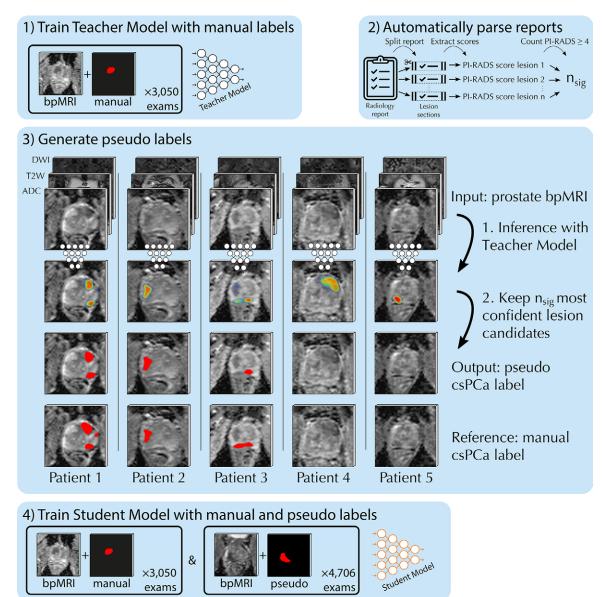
Overview of the semisupervised learning method for malignancy detection: (1) train the teacher model with manual labels; (2) count the number of clinically significant lesions described in the report, $n_{sig'}$ (3) localize and segment the lesions, by keeping the n_{sig} most confident lesion candidates of the teacher model; (4) train the student model with manual and pseudo labels. ADC = apparent diffusion coefficient, bpMRI = biparametric MRI, csPCA = clinically significant prostate cancer, DWI = diffusion-weighted imaging, PI-RADS = Prostate Imaging and Reporting Data System, T2W = T2-weighted.
